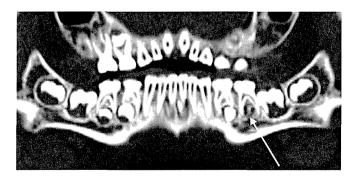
Multi-detector row computed tomography (MDCT)-synthesized panoramic radiograph of Patient 3 at 6 years of age. Note the missing lower second premolar on left side (arrow).
